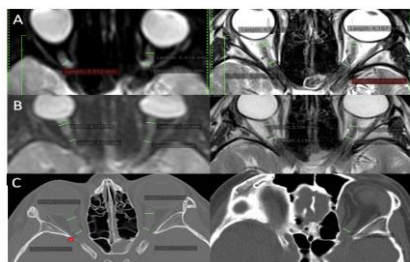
MRI images of a 9-year-old boy: thickness is 2 mm.
